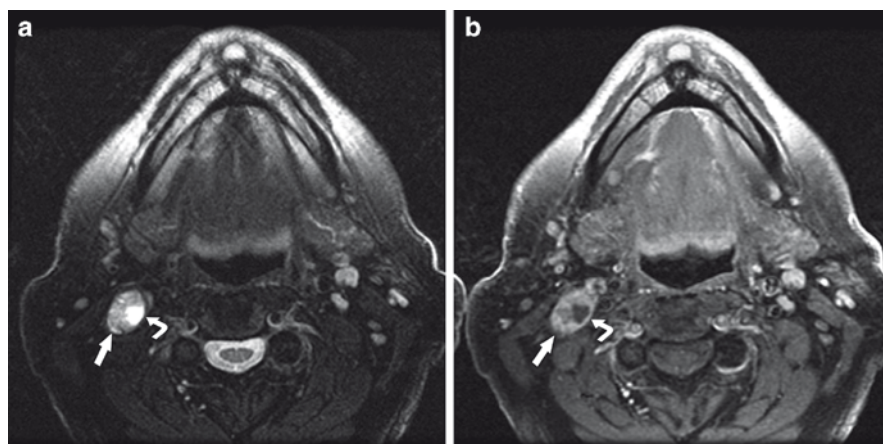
MR images of necrotic nodal metastasis. (a, b) T2-wighted and post-contrast T1-weighted MR images, respectively, show a right upper internal jugular nodal metastasis (*straight arrow*). As with reactive and benign nodes, T2 hyperintensity is typical, but this metastatic node is enlarged, and there is a medially situated focus of internal necrosis that is seen as even greater signal hyperintensity on T2, and nonenhancement on the post-contrast image (*curved arrows in a and b, respectively*)
